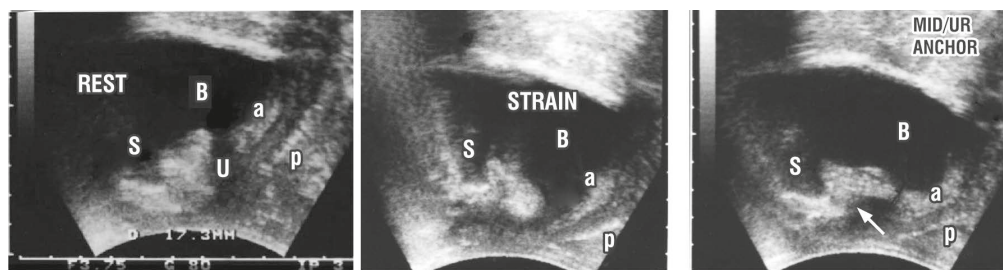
Direct ultrasound proof of Gordon's Law applied to lax pubourethral ligament 'PUL'¹⁰.
